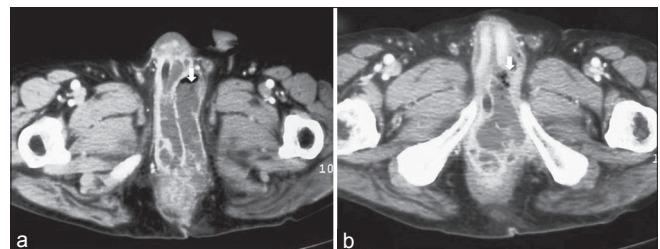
Computed Tomography scan showing abscess in the region of corporal bodies (a) and root of penis (b) with presence of air foci
